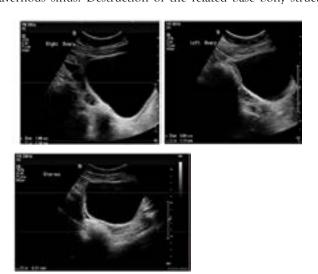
Abdominal ultrasonography before treatment showing an infantile uterus and ovaries.
